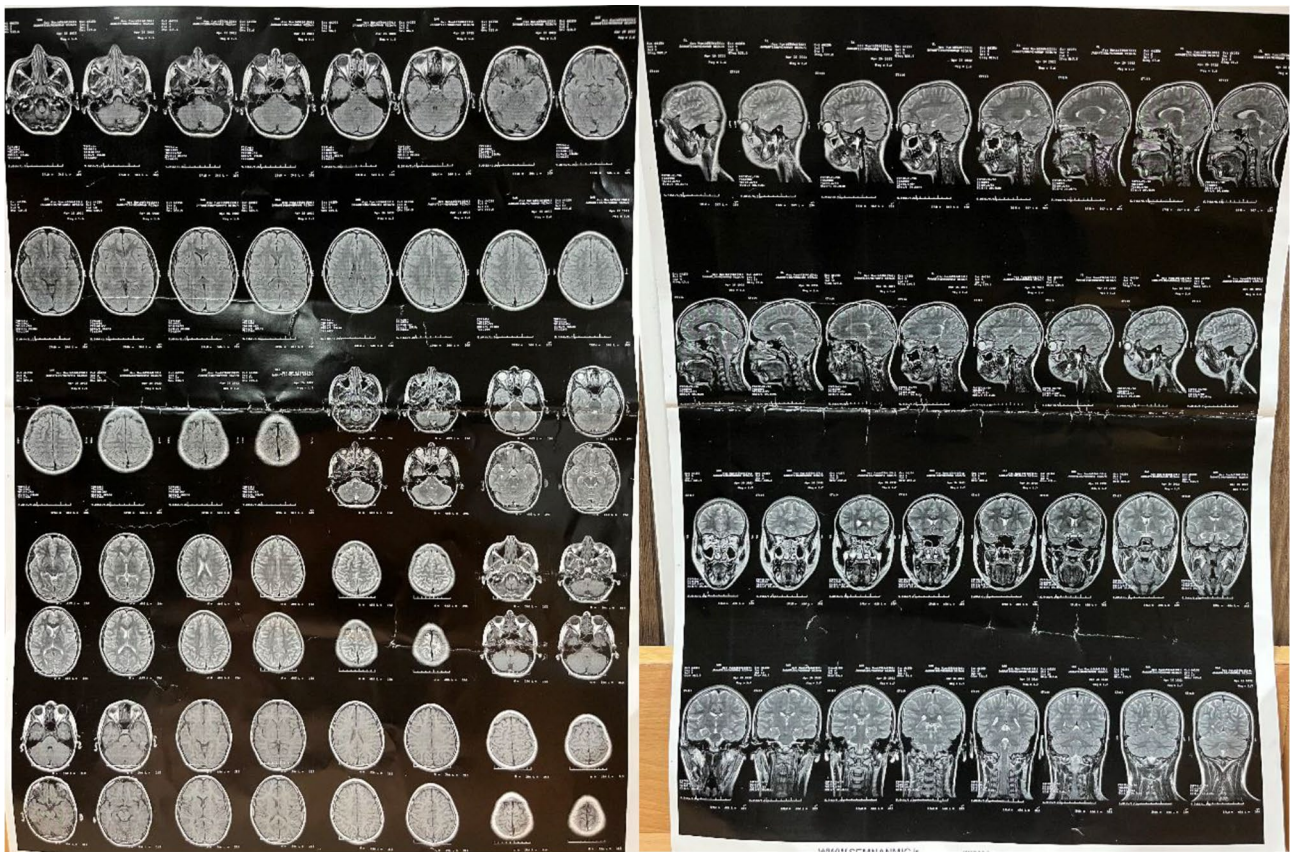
Brain MRI of our patient affected with Lafora disease
